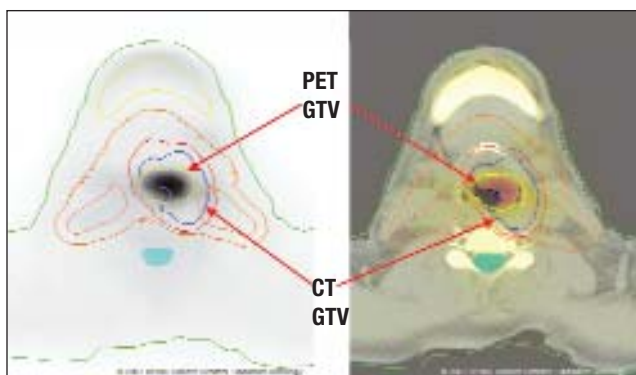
PET/CT-based GTV contours. PET information shows smaller GTV when compared with CT-based volume for laryngeal cancer.
